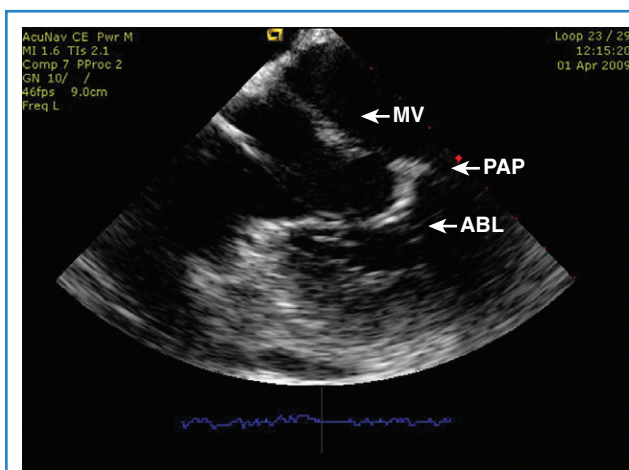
Intracardiac echocardiography image of the left ventricle in longitudinal view. Note the mapping or ablation catheter (ABL) crossing the mitral valve (MV) with its tip in contact with a papillary muscle (PAP).
